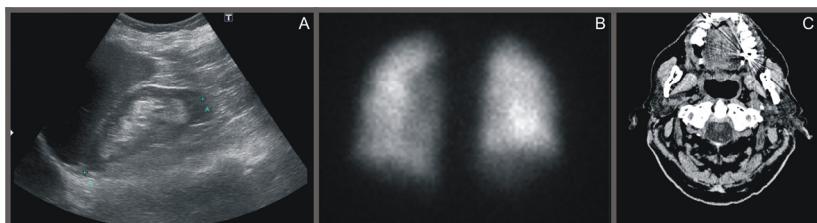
Examples of effects that can affect structure identification can be seen in the three images: (A) kidney in Ultrasound (US), (B) lung in Nuclear Medicine (NM) and (C) brain in Computed Tomography (CT). The noise associated with each image modality has to be dealt with in different ways. In image (C) the presence of dental metal pieces degraded the reconstructed slice of the brain (images acquired at the Imaging Department - Heart Institute - HCFMUSP- with patient anonymization).
